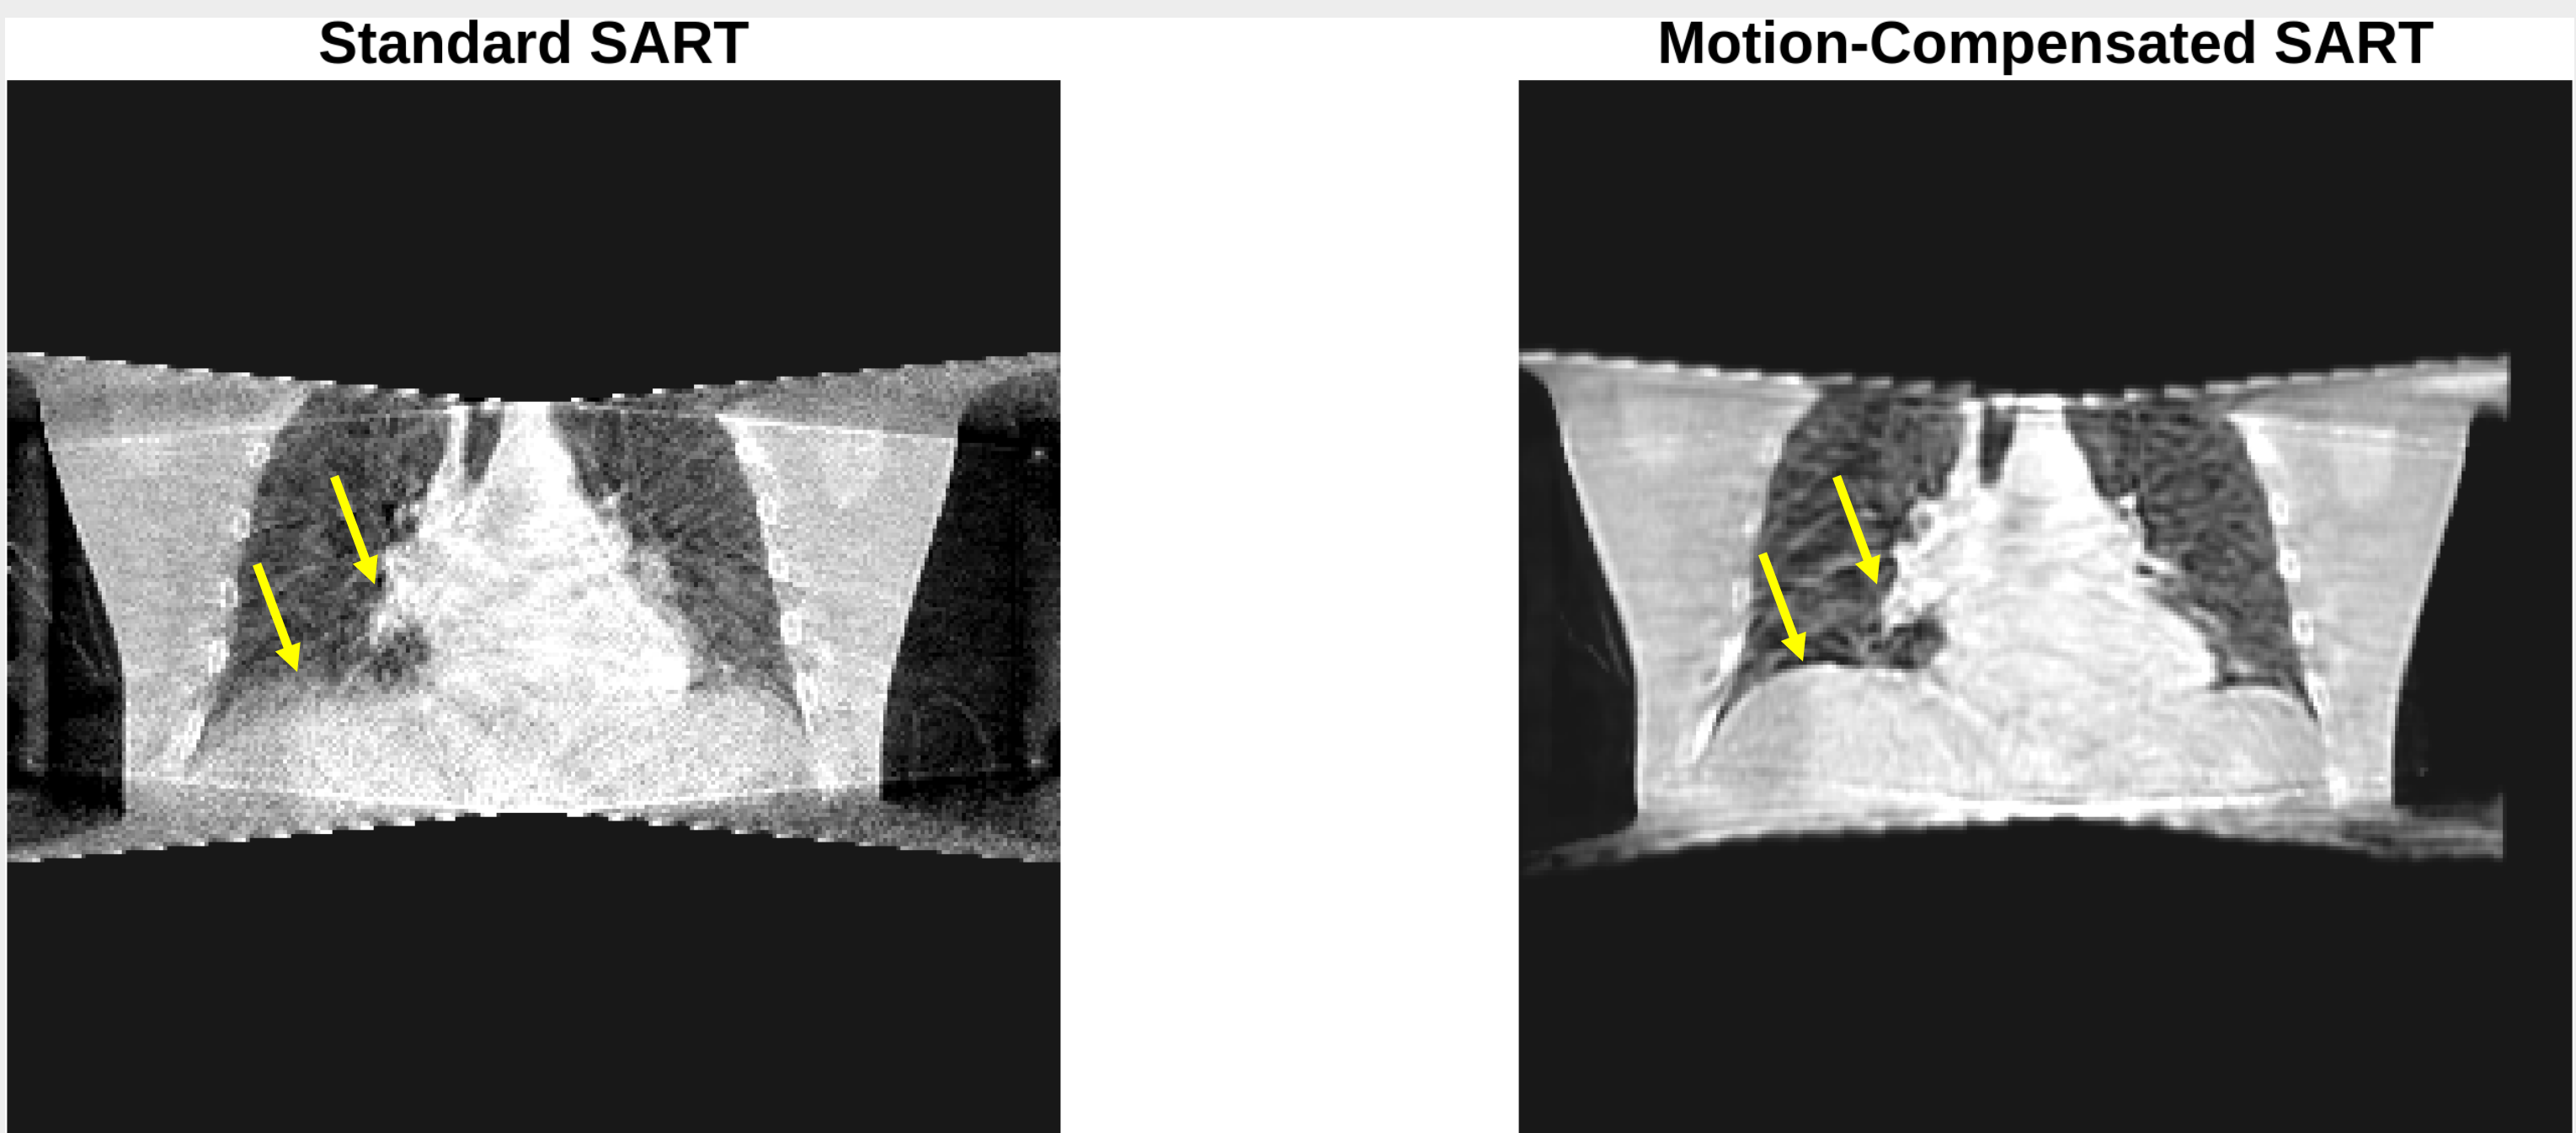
Coronal CBCT, fraction 1: standard SART (left) vs motion-compensated SART (right). mcSART sharpens diaphragm, lung, and tumor margins blurred by motion. Arrows point to example areas where the image-quality increase is apparent. The window and level are identical for the two images.
